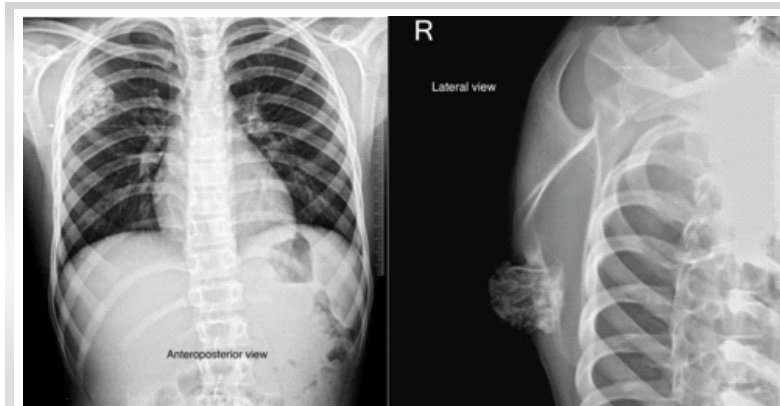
Roentgenogram anteroposterior and lateral views depicting bony outgrowth from the dorsomedial aspect of right scapula.
